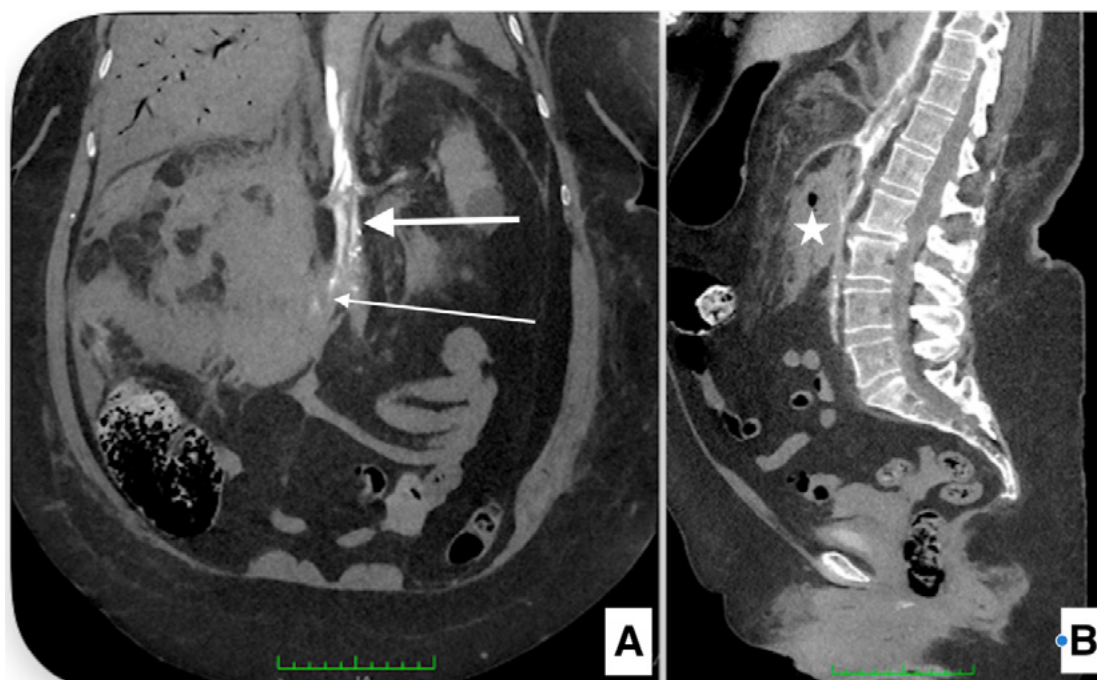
Post-mortem CTA. A: thick white arrow indicating the infrarenal abdominal aorta and thin white arrow depicting the point of aortic rupture. B: white star depicting the large retroperitoneal hematoma.
